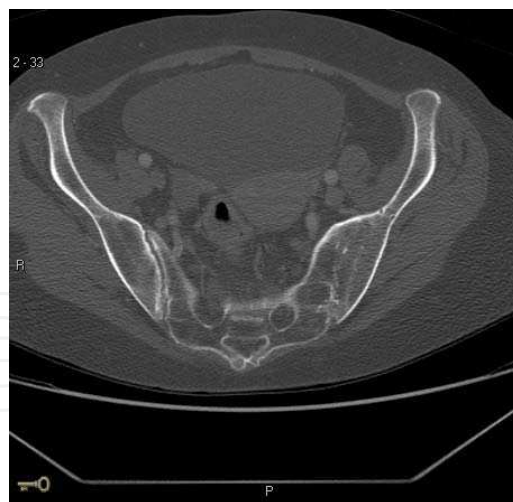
MRI showing right sided SI and fused left sided joint space
